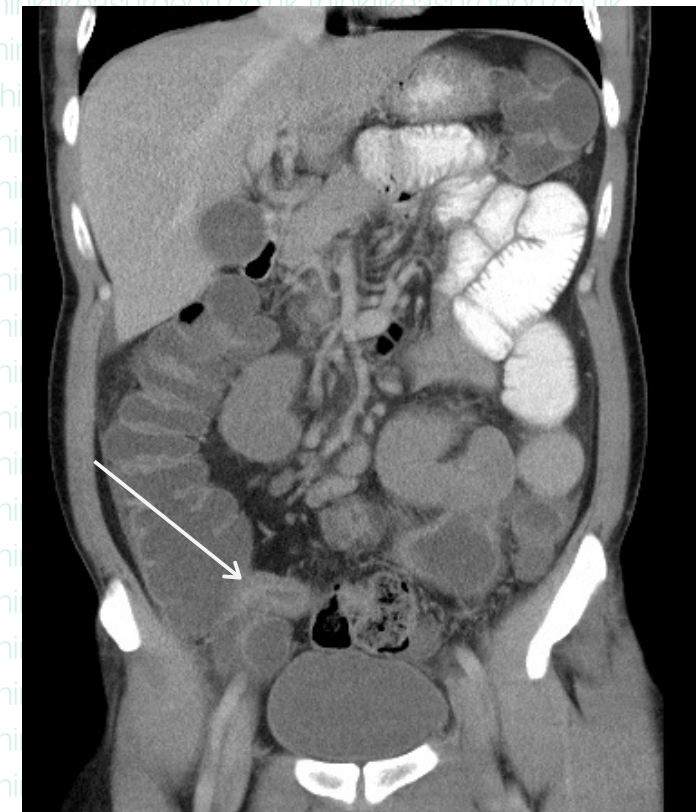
Above - CT AP coronal view showing Ileo-caecal crohn's causing S.B.O (Case courtesy of Dr Andrew Dixon, Radiopaedia.org, rID 17062)
